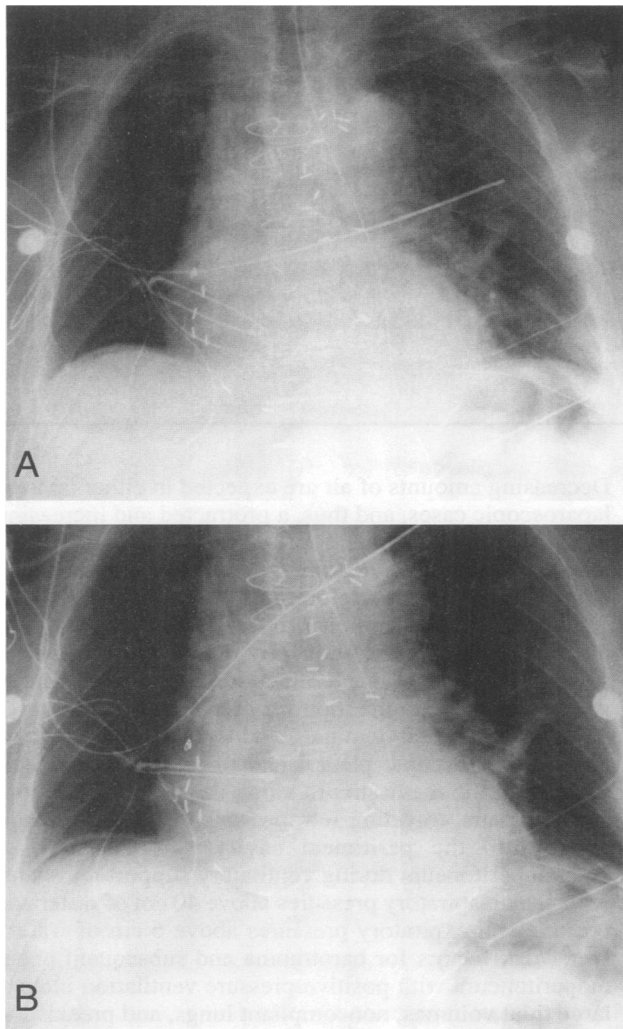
Serial chest radiographs before (A) and after (B) nasogastric air insufflation of 600 ml, without a demonstrable increase in pneumoperitoneum (Patient 7).
